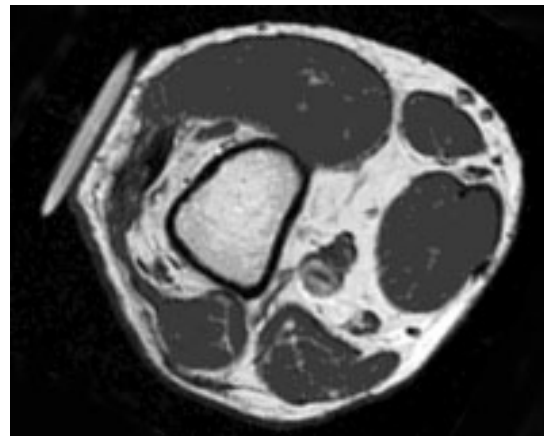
VMO in ultrasound and corresponding MRI image.
